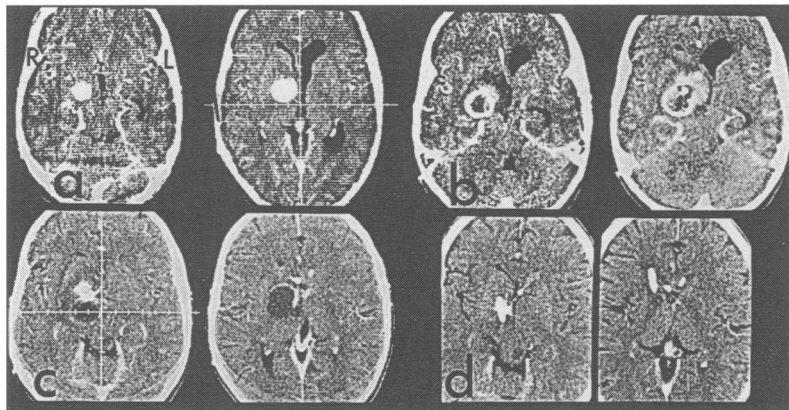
Axial enhanced CT scans of patient 7 with dystonia of the left arm due to a grade I astrocytoma located predominantly in the right pallidum and subthalamic region. The patient has a second tumour extending from the quadrigeminal plate to the pons and cerebellum. a) Before interstitial radiocurietherapy. b) 8 months after implantation of a ^{125}I seed a cyst developed. c) 18 months after interstitial radiotherapy the cyst enlarged. At that time, dystonia and hemiparesis had increased further. d) 24 months after interstitial radiotherapy the cyst was aspirated stereotactically and a drainage was placed. The dystonia and the hemiparesis improved significantly.
